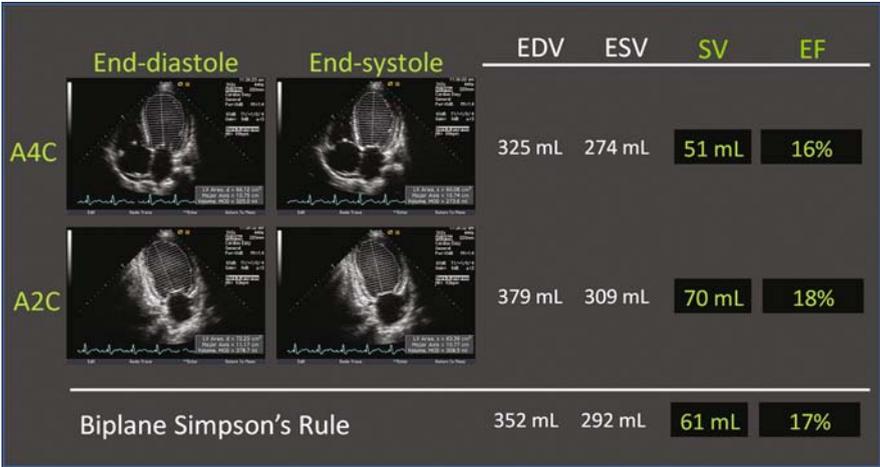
Calculation of left ventricular ejection fraction (LVEF) by biplane Simpson's rule. The operator of an ultrasound system is required to trace the endocardial border of an end-diastolic and an end-systolic frame in the apical four-chamber (A4C) and two-chamber (A2C) views. The system then calculates the end-diastolic volume (EDV), end-systolic volume (ESV), stroke volume (SV), and LVEF
